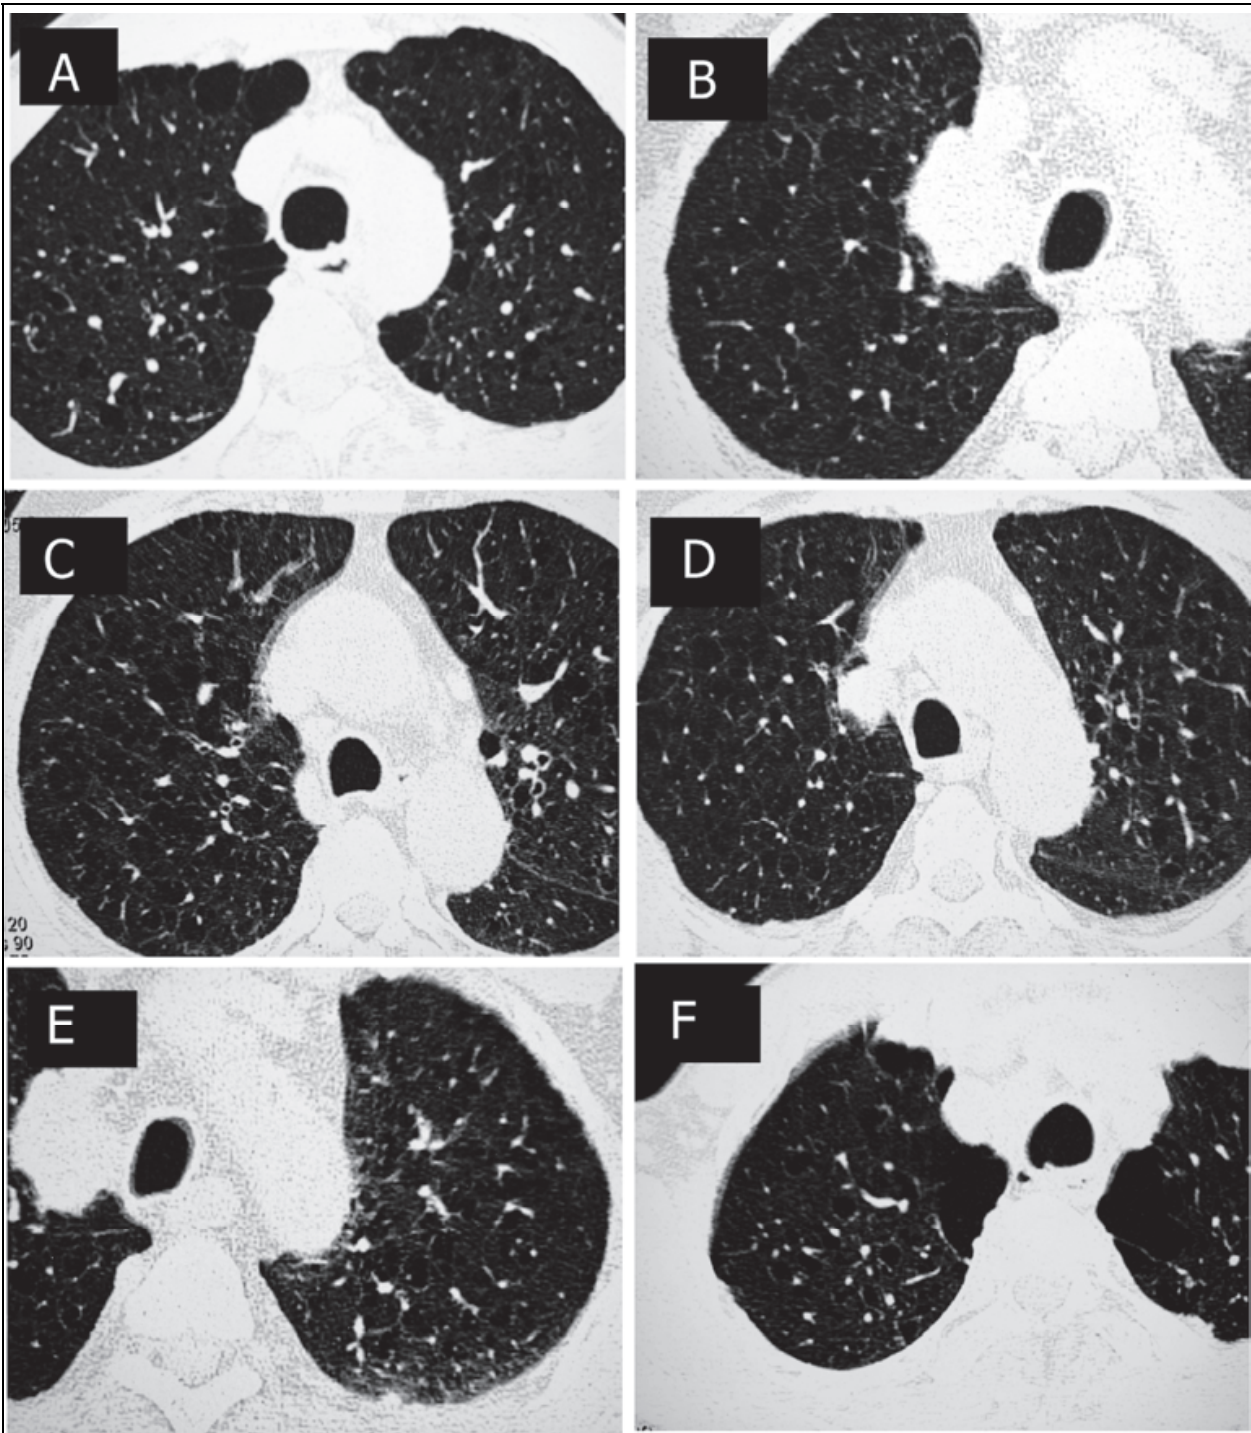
HRCT scans in patients with centriacinar emphysema showing multiple, round lucent regions of various sizes surrounded by normal parenchyma (A-F).
